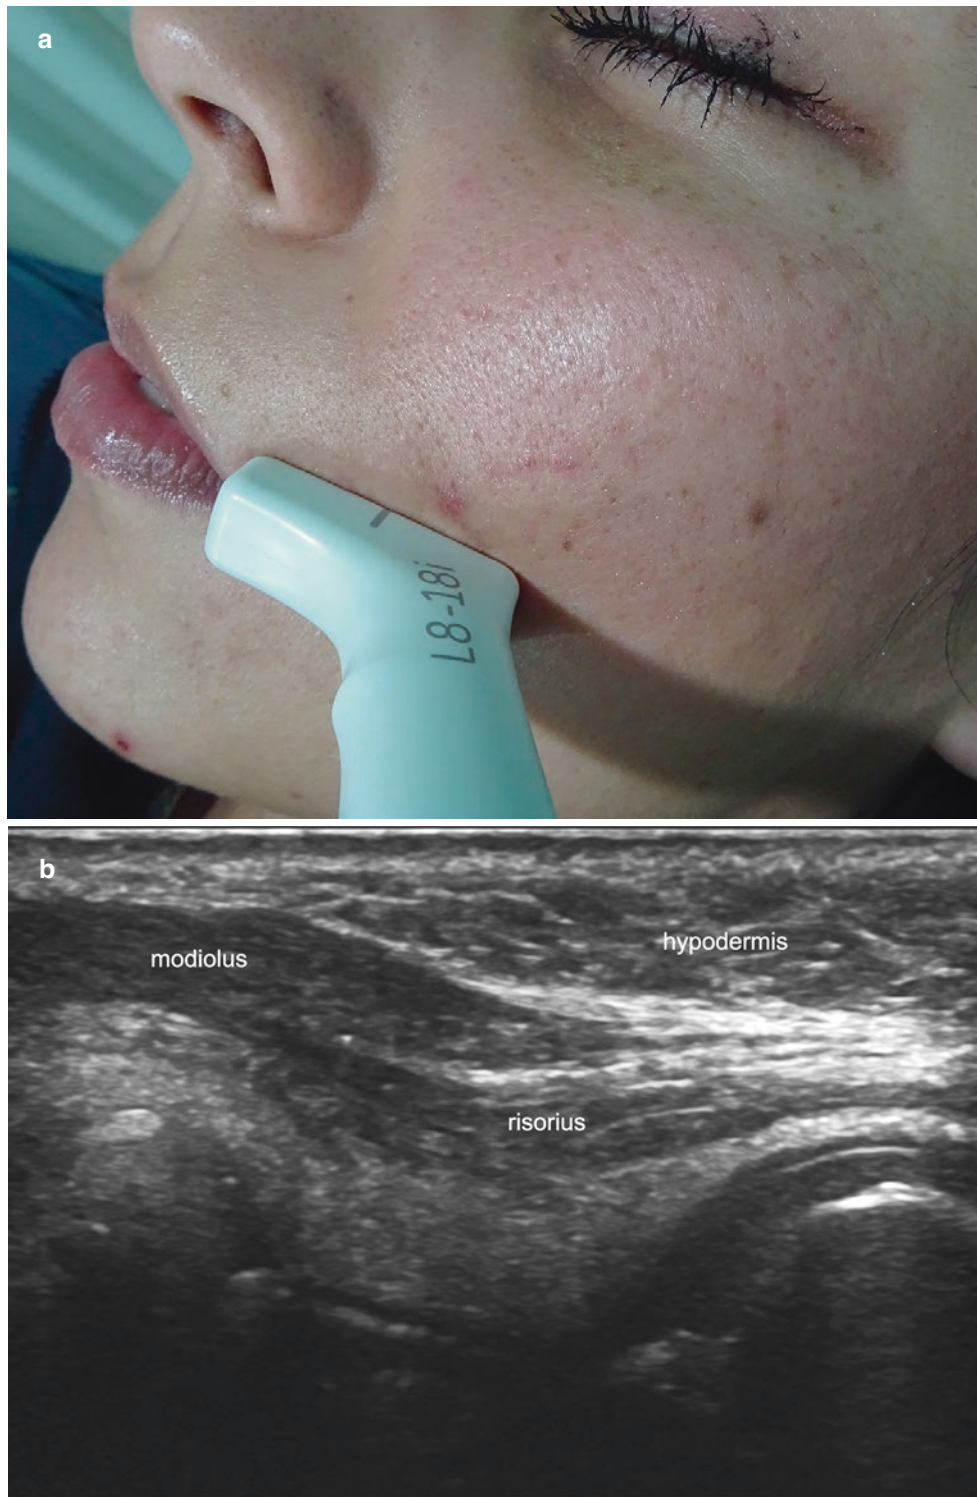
Risorius muscle. (a) Clinical image shows the location of the probe. (b) Ultrasound (longitudinal axis) demonstrates the hypoechoic band of the risorius muscle close to the modiolus.
